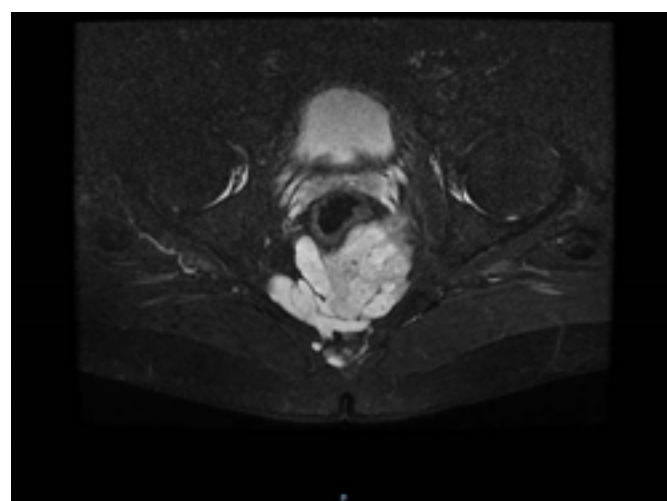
T2-weighted MRI showing hyperintensity and heterogeneity of coccyx chordoma polylobular with an anterior development around the posterior part of the rectum
